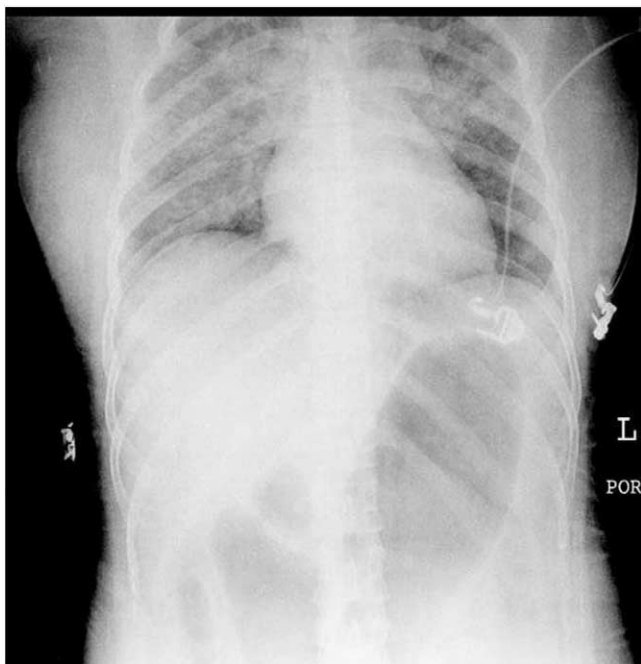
Case 1 chest radiograph showing butterfly infiltration typical of pulmonary edema.
